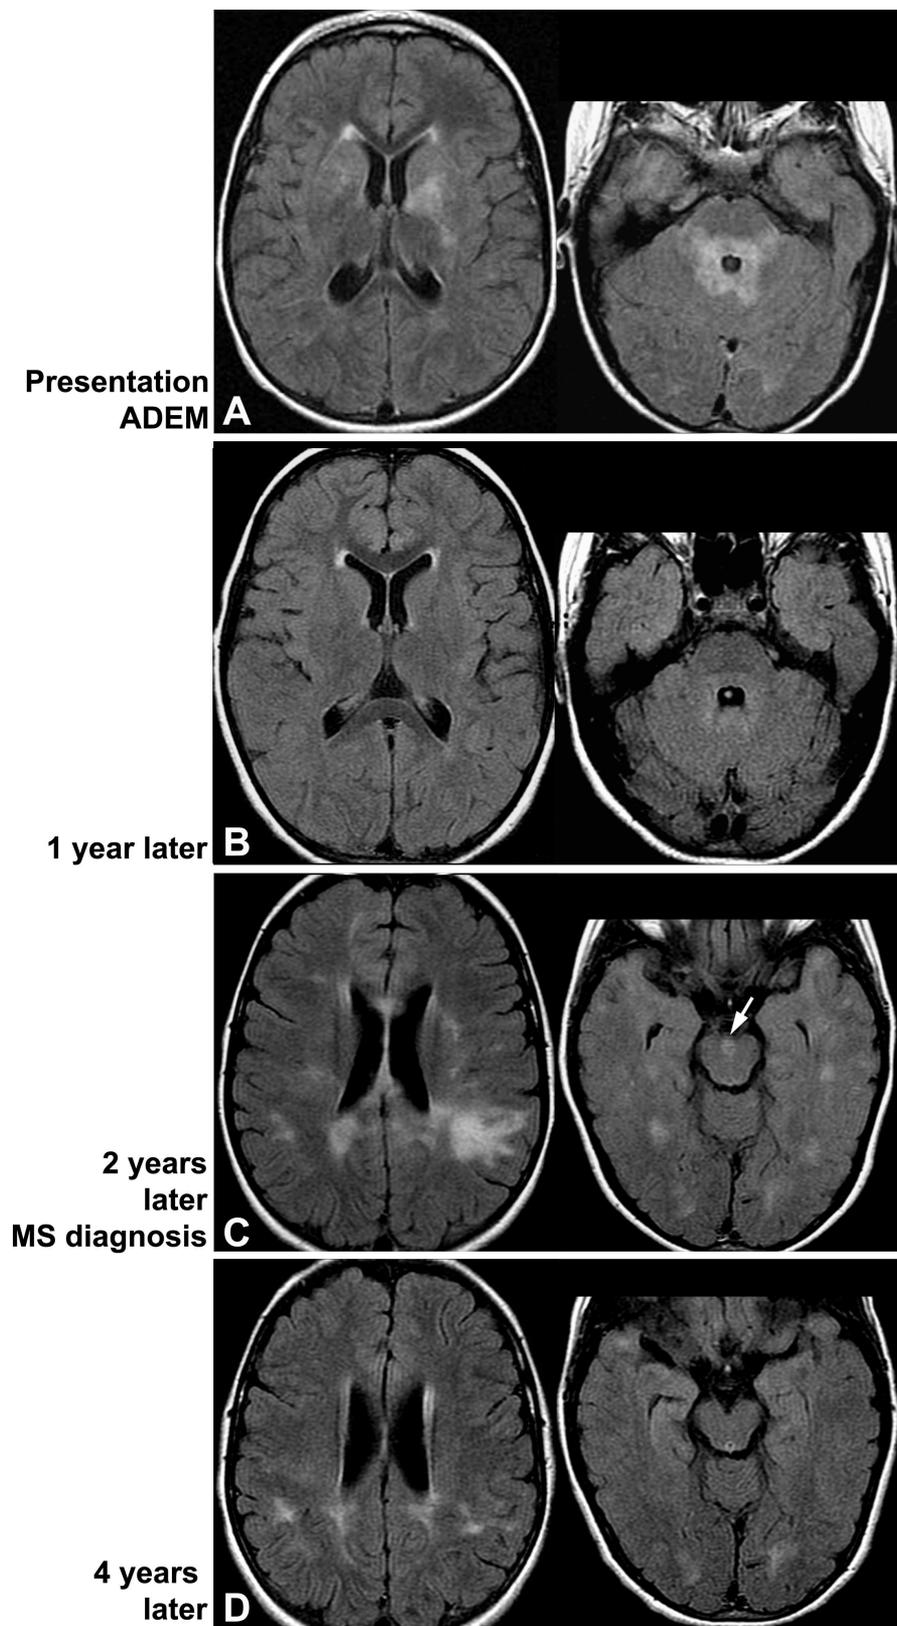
Capacity for dramatic MRI resolution of white matter lesions in children with multiple sclerosis (MS). (A) Axial fluid-attenuated inversion recovery (FLAIR) images of an 8-year-old girl presenting with acute encephalopathy, ataxia, and tremor, diagnosed as acute disseminated encephalomyelitis. Images show ill-defined increased signal in the white matter of the brainstem and cerebellum as well as the deep gray matter. (B) Axial FLAIR images of the same child obtained 1 year later. The patient was clinically well. Near complete resolution of the prior lesions in the brainstem, cerebellum, and deep white matter is noted. No new white matter lesions are present. (C) Axial FLAIR images 2 years after her initial presentation demonstrate new lesions in the brainstem (arrow), periventricular white matter, and splenium of the corpus callosum. The patient presented with new neurologic deficits (without encephalopathy) and was diagnosed with MS. (D) Axial FLAIR images obtained 4 years after her initial presentation (2 years after the MRI shown in C). Although there has been considerable resolution of some of the prior lesions, improvement is not as dramatic as the near-complete MRI lesion resolution noted in B, suggesting that remyelination capacity may diminish either with increasing disease duration or with increasing age. The child has experienced four MS relapses, and the MRI shown in D was obtained with the child on therapy with glatiramer acetate.
